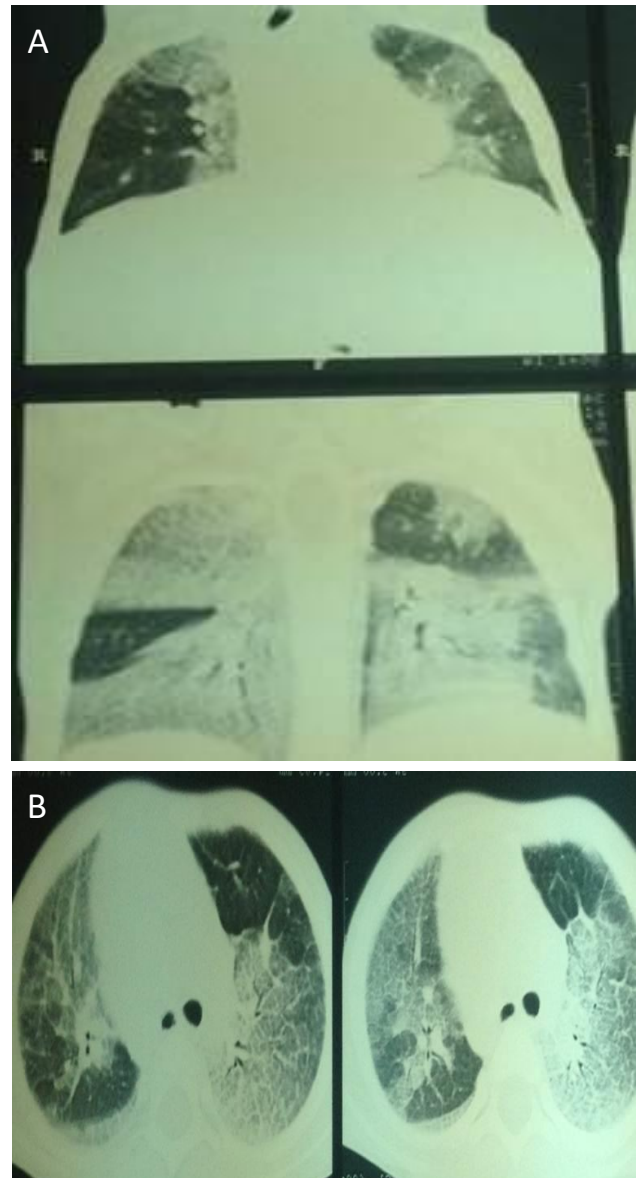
CT scan chest showing features of interstitial lung disease
